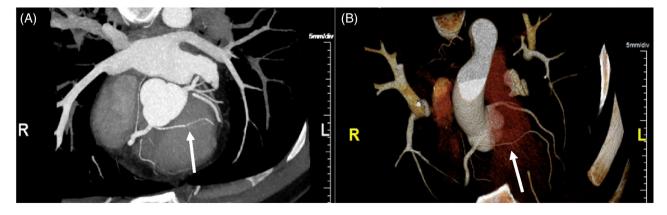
(A) Coronary CT angiography with anomalous left anterior descending system arising from the right coronary artery cusp (white arrow) (B) Coronary CT angiography reformat showing anomalous left anterior descending artery arising from the right coronary artery cusp (white arrow). CT, computed tomography.
